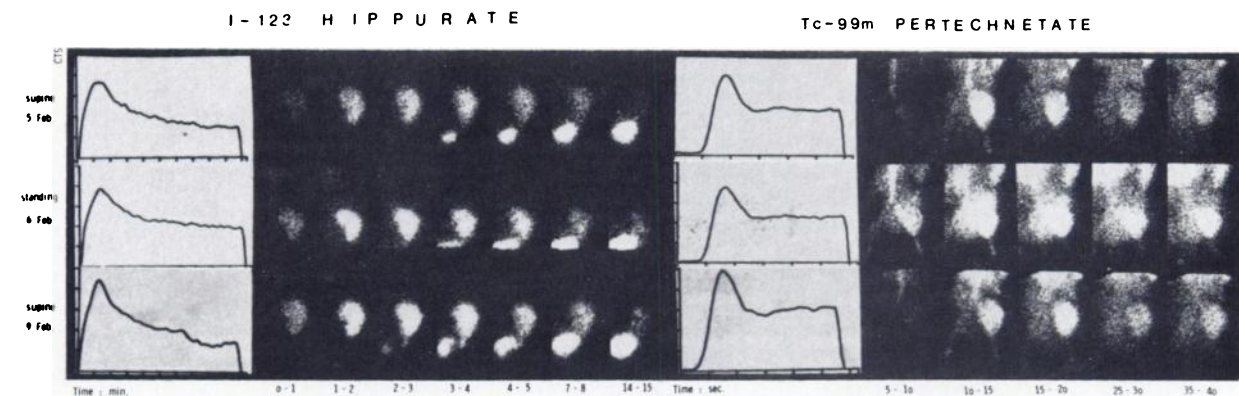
Patient 25 again: iodohippurate renography and pertechnetate perfusion scintigraphy in supine and standing positions. Sequence shows that change in posture will not necessarily influence renography. Intrarenal iodohippurate transport, as judged by tissue activities at 3 and 14 min, is stable; so is bladder appearance time. Change in posture did not influence pertechnetate time-activity curve in this normotensive patient.
